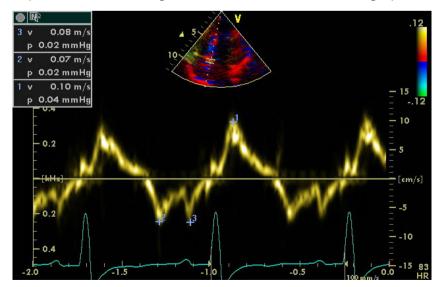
Septal Tissue Doppler imaging (TDI) tracing in a Patient with HCM
